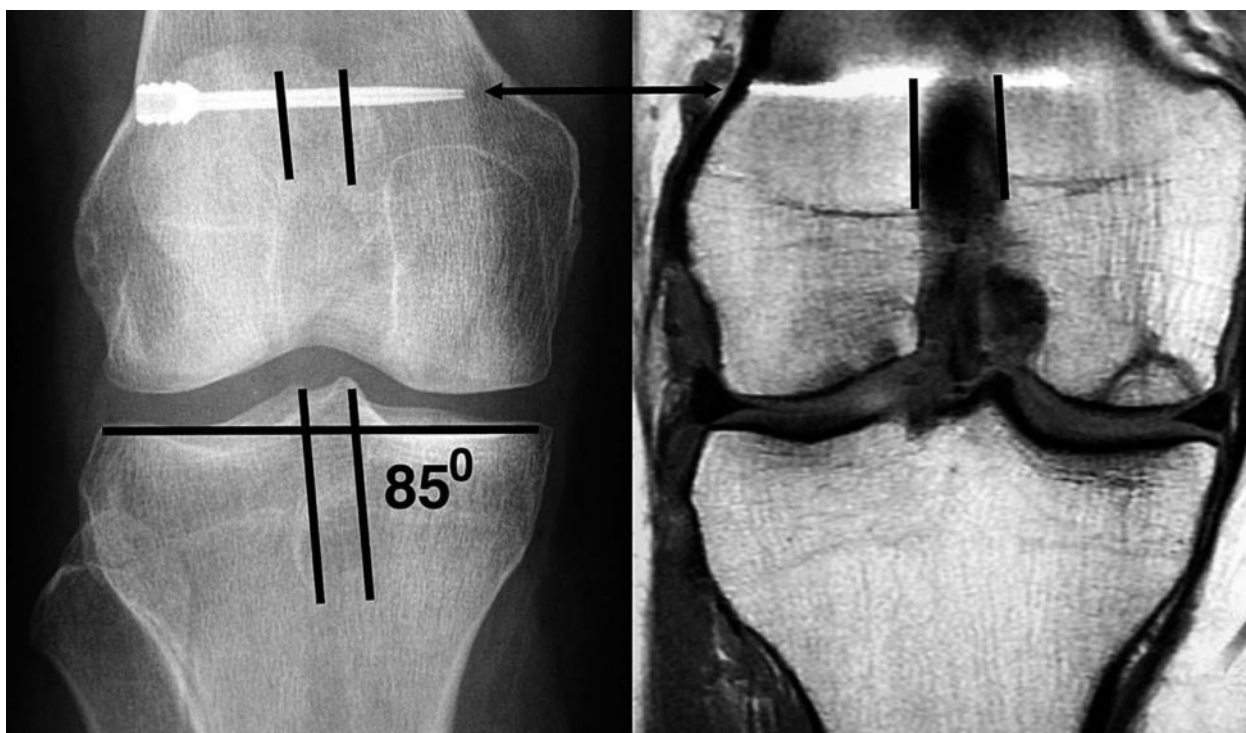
The patient with this anteroposterior radiograph and coronal magnetic resonance image complained of the inability to fully flex the knee. The anteroposterior radiograph was diagnostic of posterior cruciate ligament impingement because the angle of the tibial tunnel with respect to the medial joint line was greater than 70° . The coronal magnetic resonance image was diagnostic of posterior cruciate ligament impingement because the femoral tunnel was at the apex of the notch and there was no space between the posterior cruciate ligament and anterior cruciate ligament graft at the apex of the notch. The tibial tunnel should have been placed at 60 to 65° with respect to the medial joint line of the tibia to prevent posterior cruciate ligament impingement.
